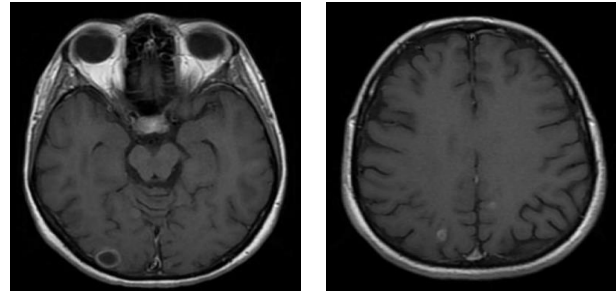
MRI 4 weeks after conservative treatment. Regression of the lesions.
